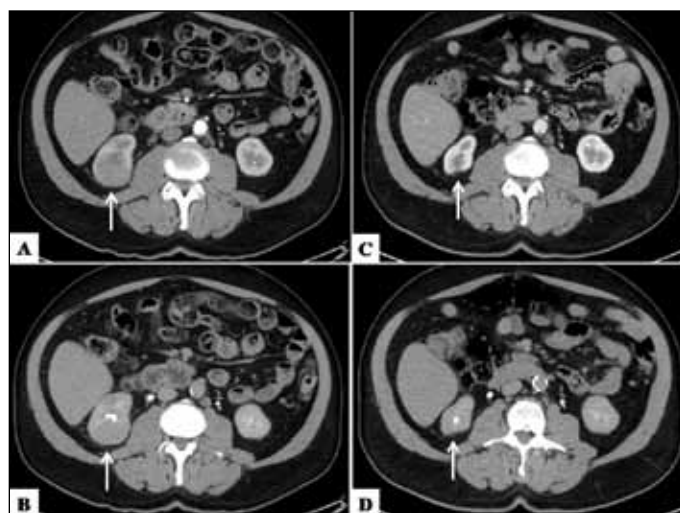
Case 1: Axial CT images through the lower poles of the kidneys. (A) Arterial phase images demonstrating the right lower pole enhancing lesion (arrow). (B) Delayed phase images demonstrating the "central unaffected calyx sign" (arrow). (C) Arterial phase images one year later showing resolution of the right renal mass with scarring (arrow). (D) Delayed phase images one year later showing that the lower pole calyx is unaffected (arrow).
